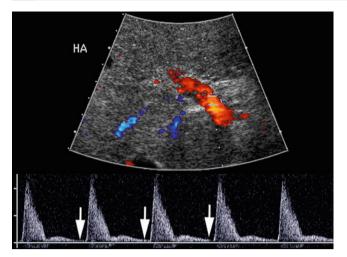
High resistance hepatic artery flow. Color Doppler sonogram with spectral waveform below of the hepatic artery in a patient with cirrhosis, demonstrating almost no end diastolic flow (*arrows*), indicative of high resistance to arterial inflow
